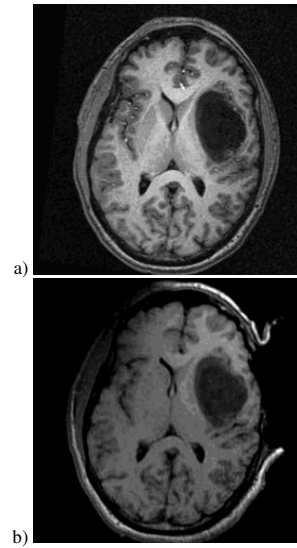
MRI images a) before opening the skull, b) after opening the skull.
